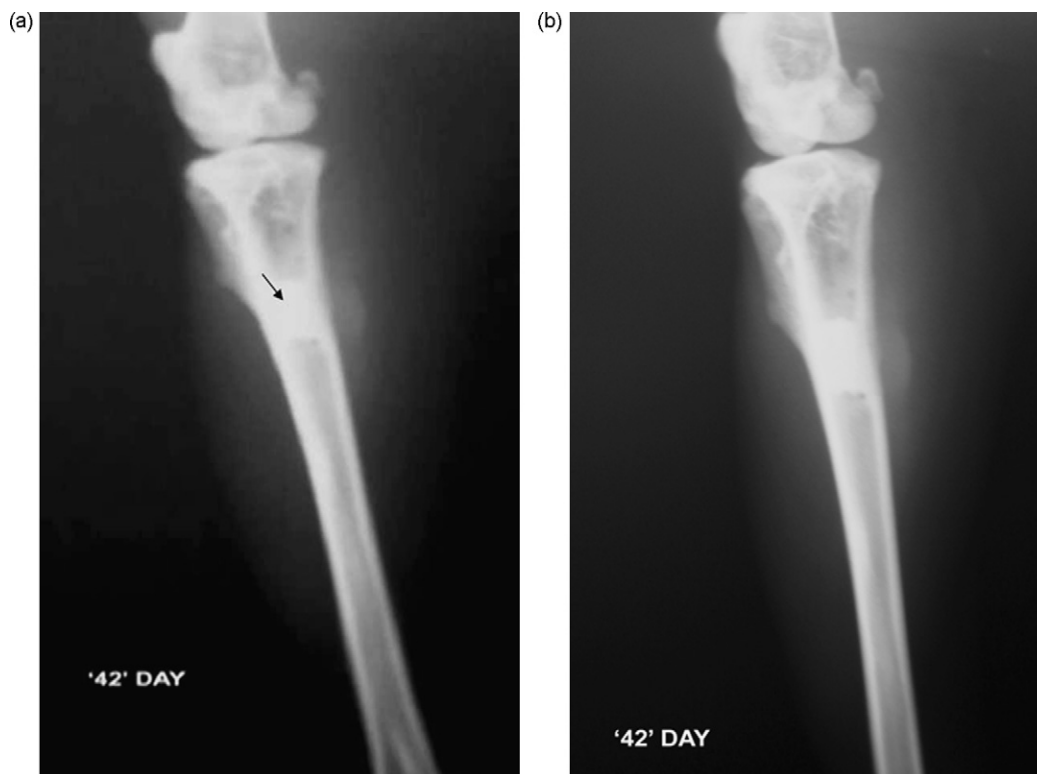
Radiograph at day 42 with antibiotic incorporated (a) HAP and (b)  $\beta$ -TCP showing recovery from the osteomyelitis changes at the adjacent areas of respective implants.
